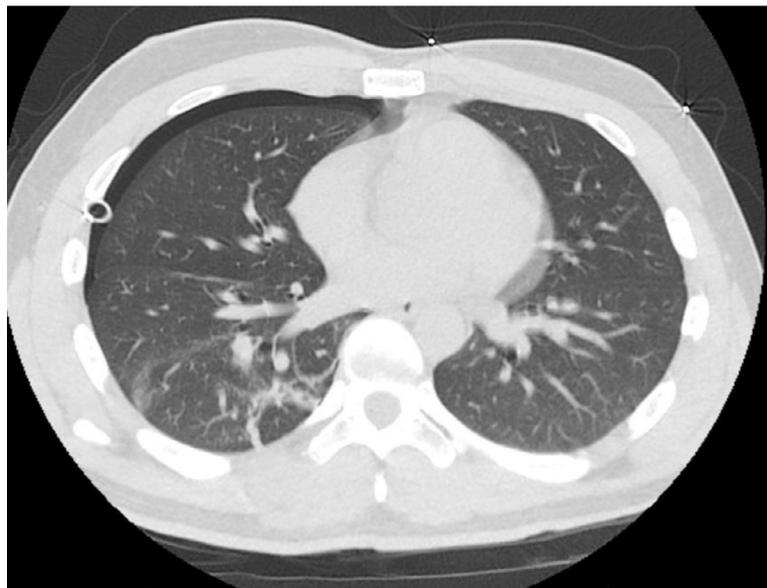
Axial computed tomography image of the chest showing re-expansion of the right lung after insertion of a chest tube.
